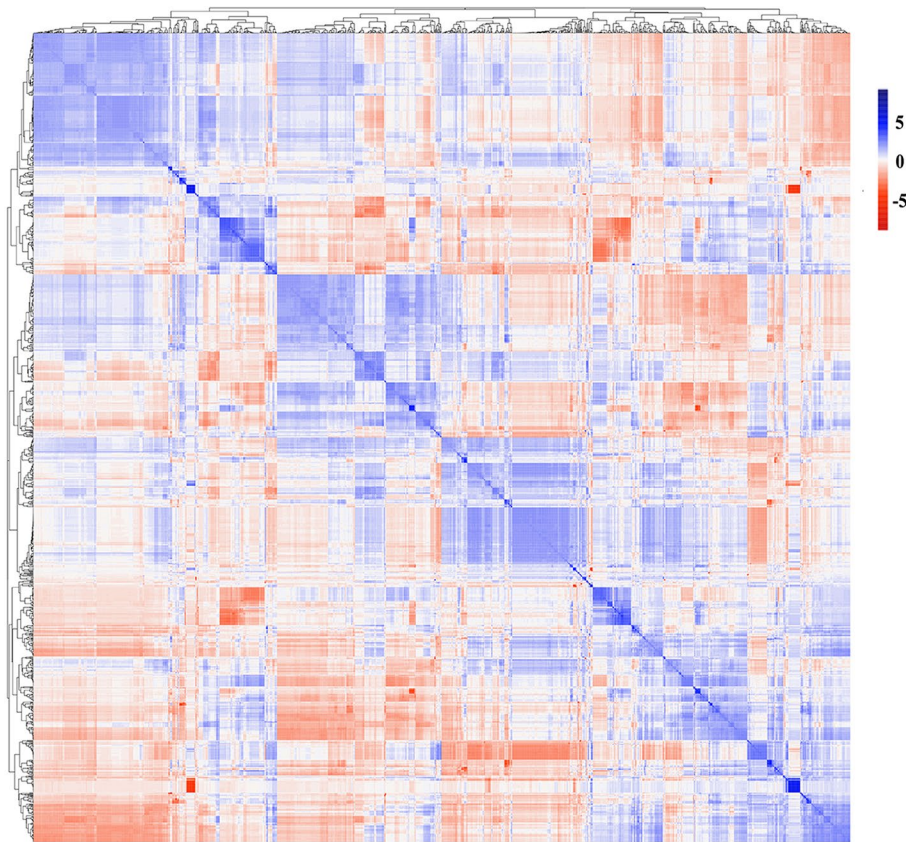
Cluster heatmap of radiomics features based on ultrasound medicine images Z-score normalization was applied to scale the quantitative expression values of 1239 extracted radiomics characteristics, and heatmap visualization was utilized to demonstrate the clustering patterns among these radiomics characteristics
